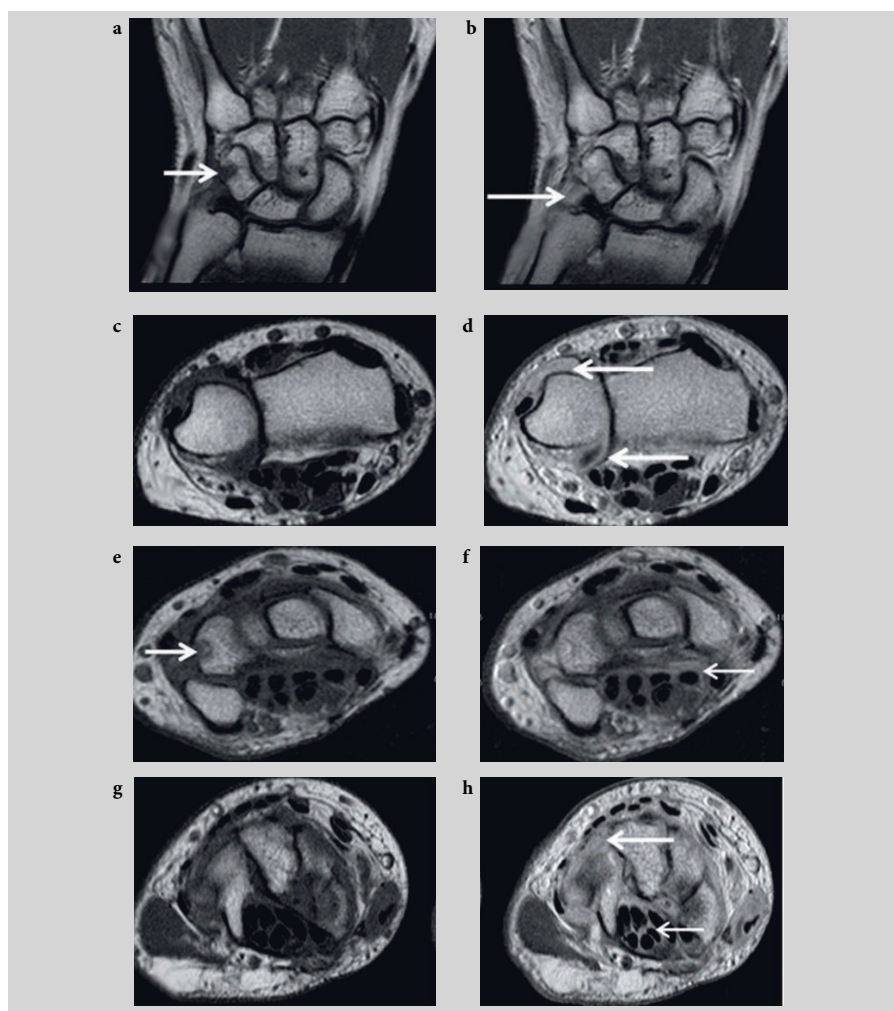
Magnetic resonance imaging (MRI) of the wrist of a patient with clinically active early rheumatoid arthritis (<6 months' duration). T1-weighted MRI in the coronal (a, b) and axial planes (c–h), before (left column) and after (right column) intravenous contrast injection. (c, d): Axial section through the distal radius and ulna. (e, f): Section through the proximal row of carpal bones. (g, h): An even more distal section through the hook of the hamate. An erosion is seen in the triquetrum (short thick arrows) in two planes. Marked synovitis is seen both in proximal and distal parts of the wrist joint (long arrows). Furthermore, flexor tenosynovitis is seen (thin short arrows).
